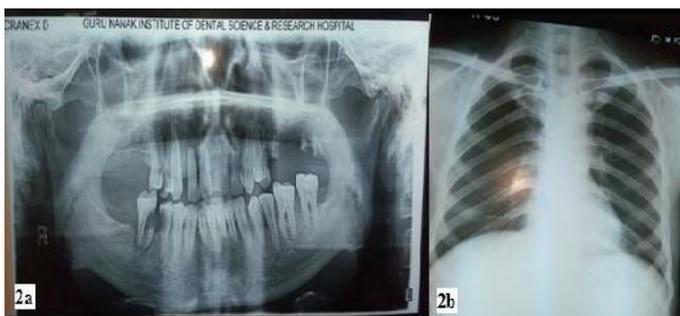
(a) Orthopantomogram showed presence of multiple carious teeth, retained roots and generalised alveolar bone loss in both jaws and (b) Postero anterior (PA) view radiograph of chest showed no abnormality
